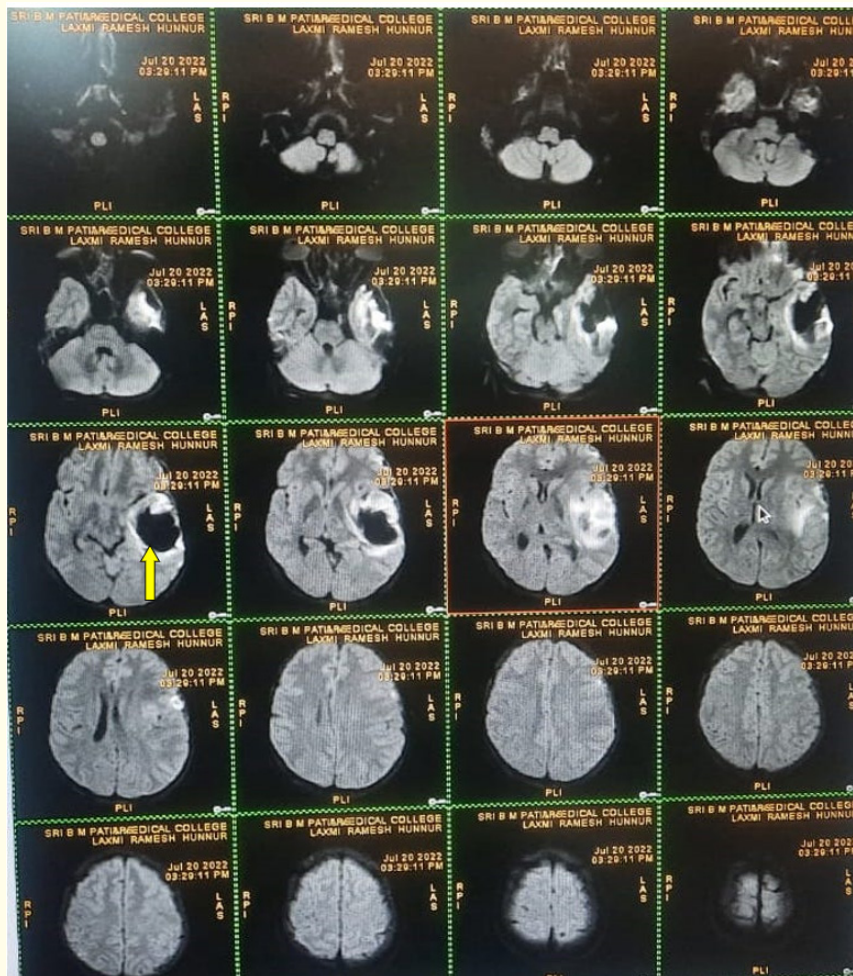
MRI Brain: Area of hemorrhagic infarct (Yellow arrow), Midline shift (arrow head).
